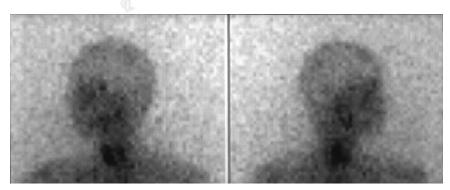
After DOTATOC treatment, ¹¹¹In-DOTATOC scintigram (left and right lateral images) revealed no enhancement. CCT finding was partial remission.
